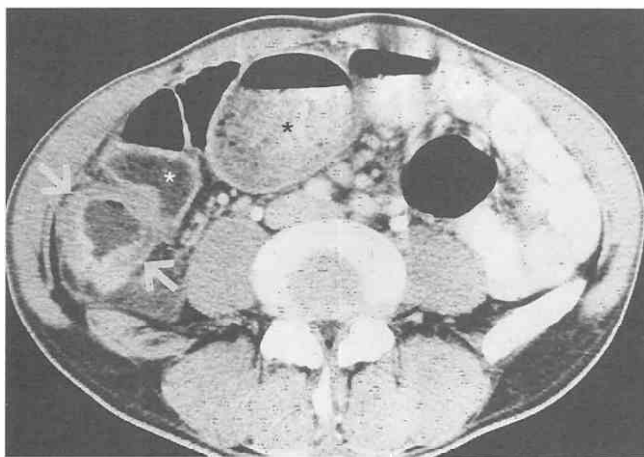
Intestinal tuberculosis. CT scan shows heterogeneous bowel wall thickening (arrows) of the ileum. The ileal loops are dilated (asterisks) as a result of bowel obstruction caused by strictures (not shown).
